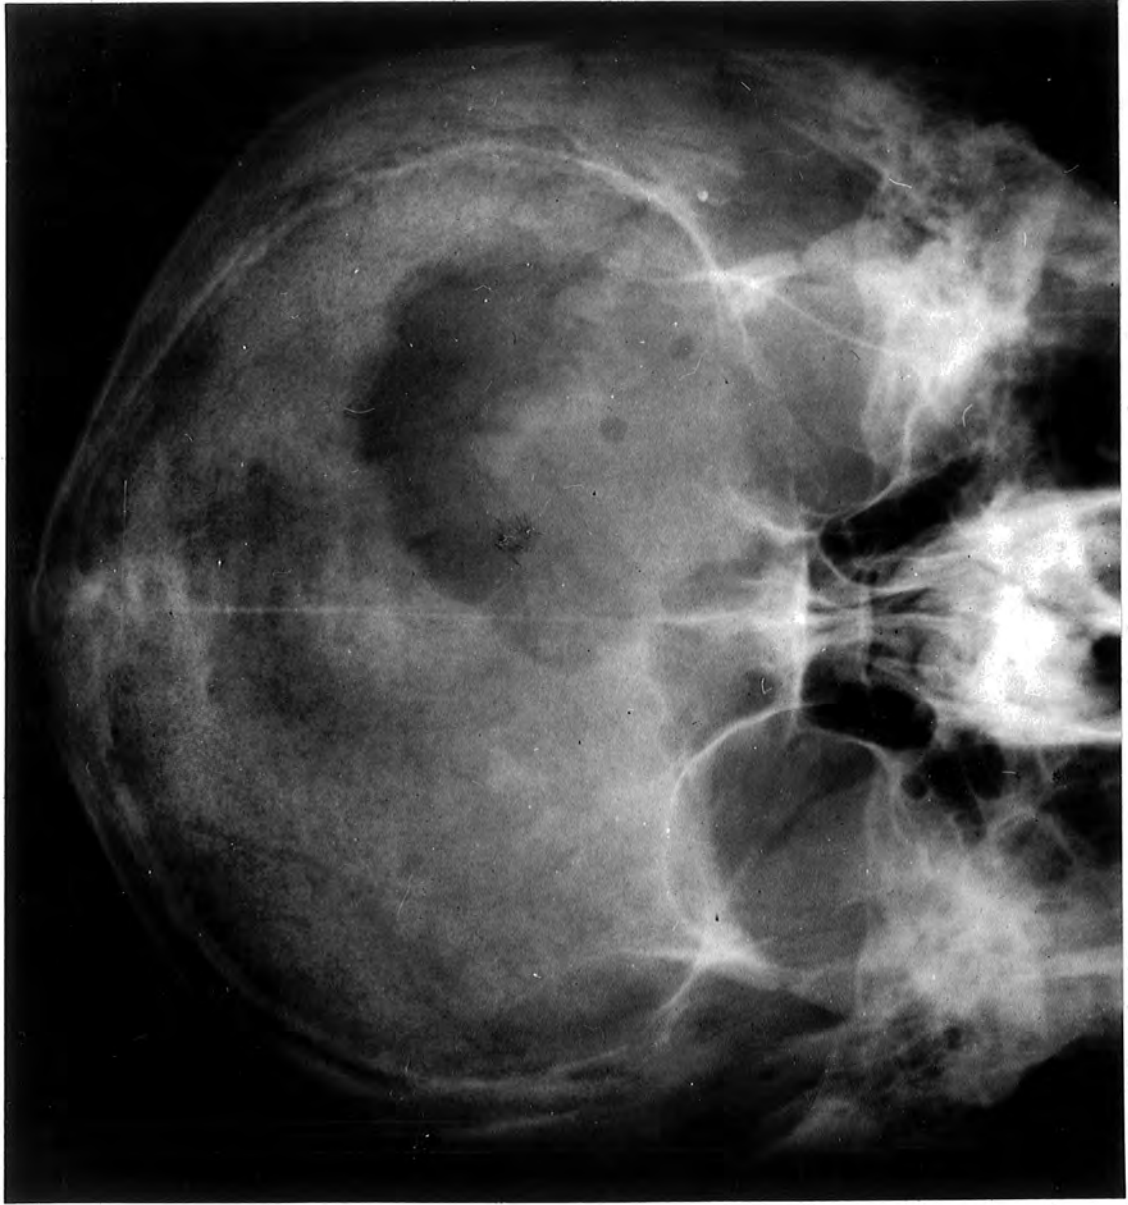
CASE SIX. Skull X-ray, A.P. view. Large left fronto-orbital myeloma.
